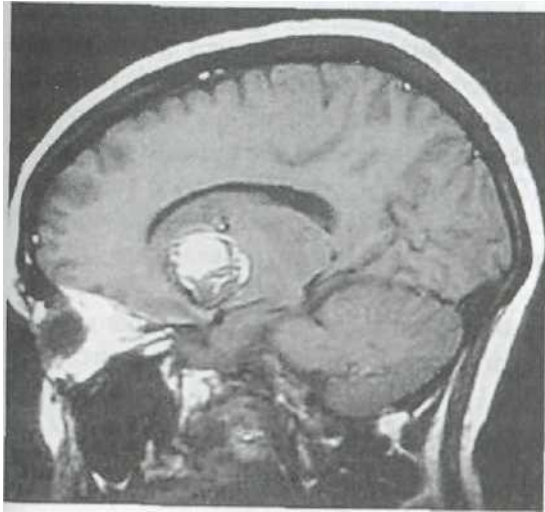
MRI of a caudothalamic cavernous malformation. Note the variegated appearance of the core caused by multiple hemorrhages of different ages and the hypointense rim caused by deposition of hemosiderin.
